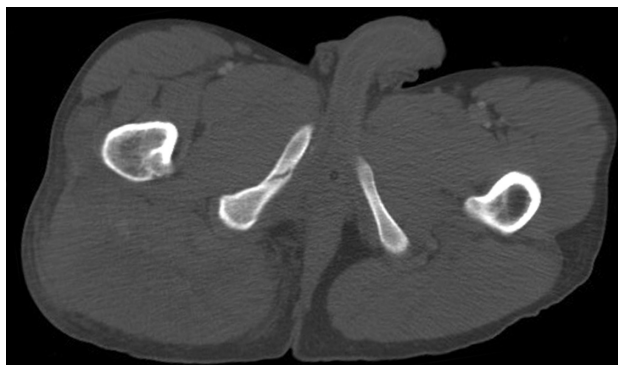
Pelvis CT image. There is a nondisplaced fracture of the right pubic ramus. Note large right gluteal hematoma.
